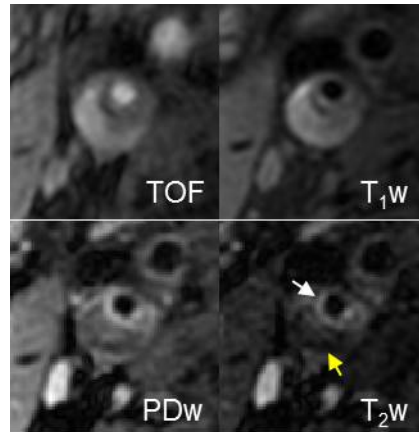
Multi-contrast MRI of carotid plaque with thin fibrous cap and large lipid core. The fibrous cap (white arrow) shows hyperintense signal on the T₂w image. The lipid core (yellow arrow) shows hypointense in the T₂w image. The images are acquired by the author.
